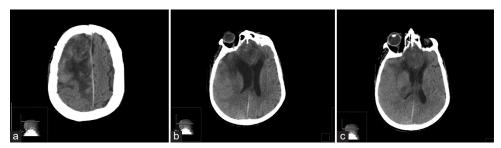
(a-c) Postoperative images show maximal meningioma debulking through ultrasonic aspiration, resolution of intracranial hemorrhage, and subsequent correction of midline shift.
